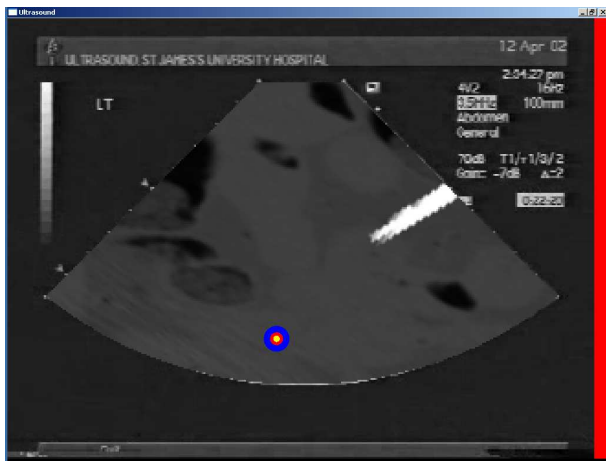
The main ultrasound window
